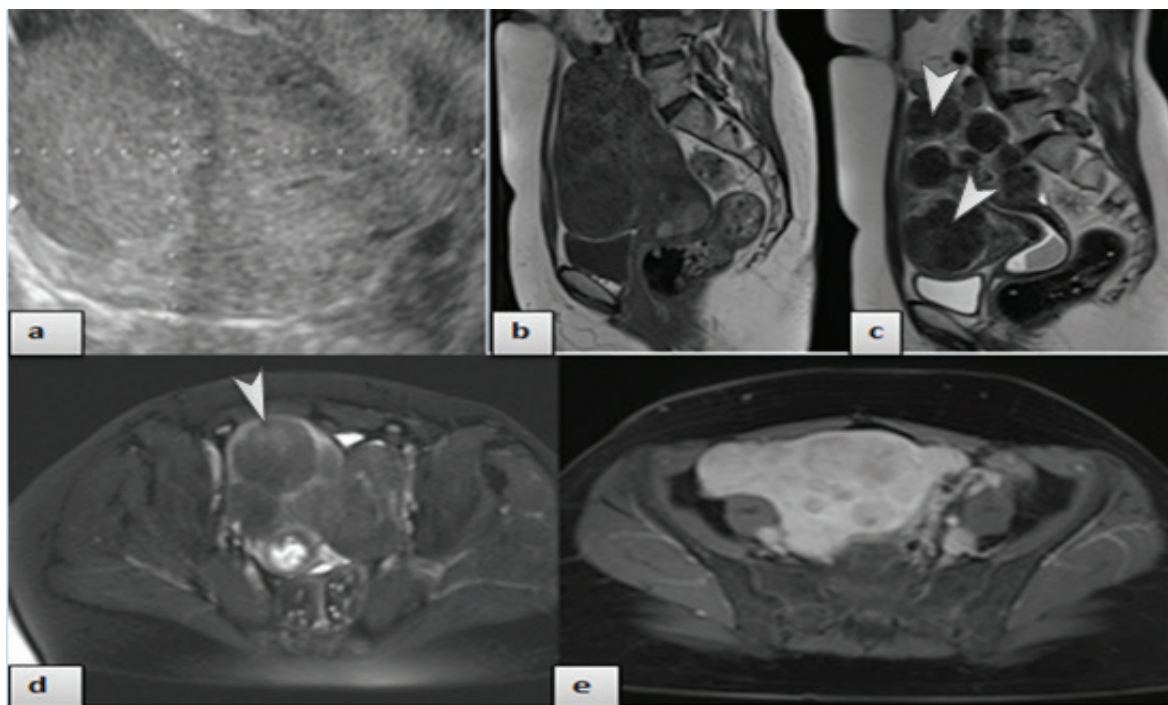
A 44-year women with leiomyoma: a) Sagittal ultrasound show intramural leiomyoma, b) MRI T1WI show isointense of leiomyoma, c) T2WI, d) T2 STIR, multiple uterine leiomyomas, shows multiple well-defined hypointense masses, some of which have a characteristic thin hyperintense rim (arrowhead). d) T1 post contrast, demonstrates hypoenhancement of mass post contrast.
